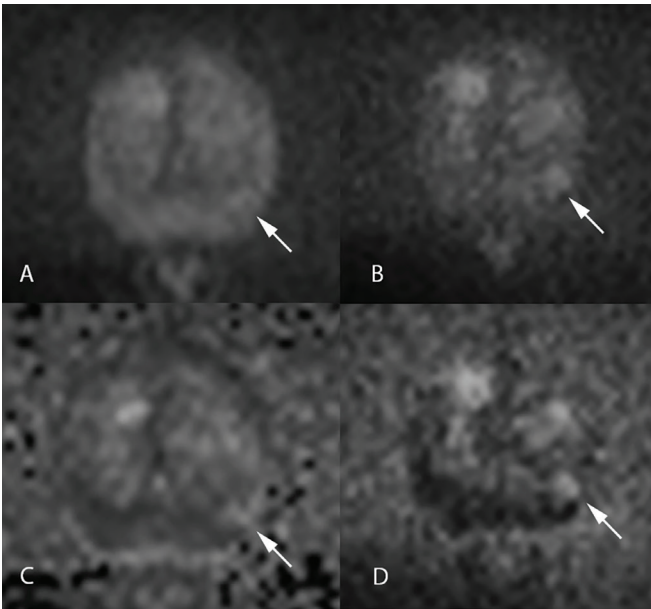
Figure A shows b800, B shows b1400 DWI, C shows computed b1400 and D shows computed b2000 DWI. Although the computed b1400 image is not as good as the original b1400, the computed b2000 DWI demonstrates the lesion better (arrow)
